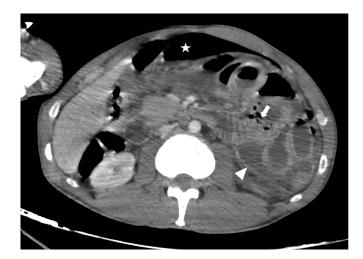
Axial image of an abdominal enhanced CT scan revealing an important pneumoperitoneum (asterisk), a parietal defect in the jejunum in favor of a perforation (white arrow), and a thickened peritoneum with loculated ascites (head arrow).
